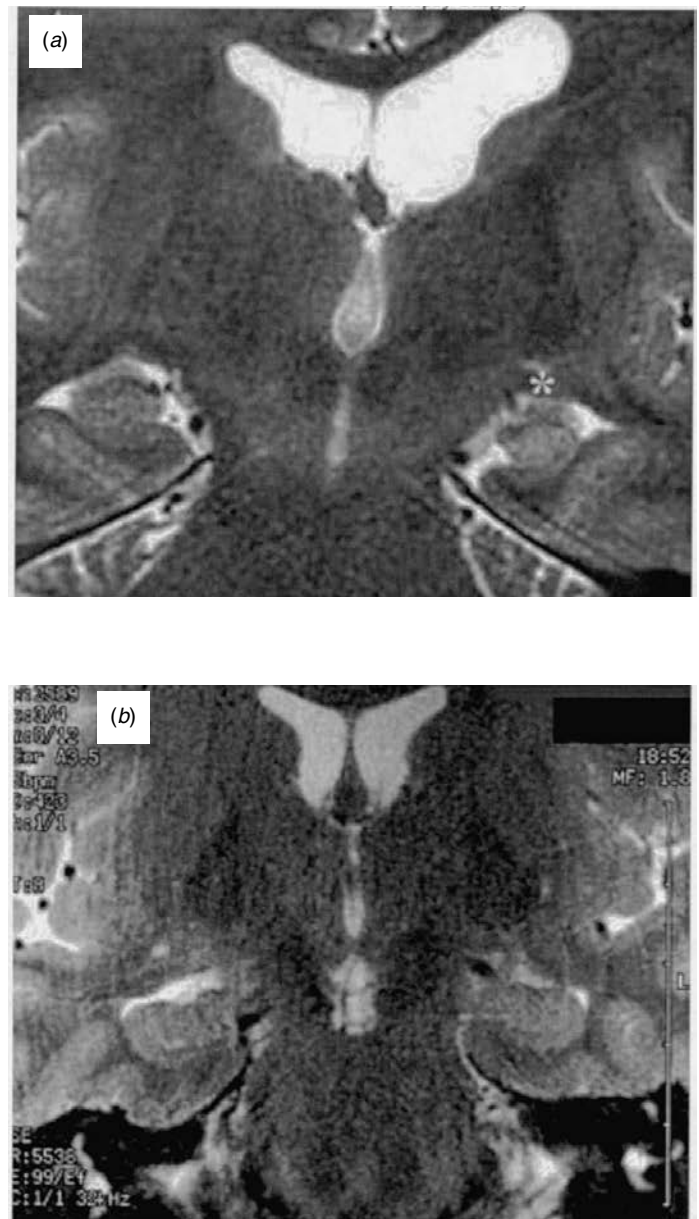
Representative coronal MR image from a patient with mesial temporal sclerosis (a) and a patient with MR symmetric hippocampi (b). The hippocampus with the atrophy and increased signal is marked with an asterisk. Both of these patients presented with mesial temporal lobe epilepsy. The preoperative prediction of seizure freedom following surgery is 80–90% for patient (a) and 50–60% for patient (b).
